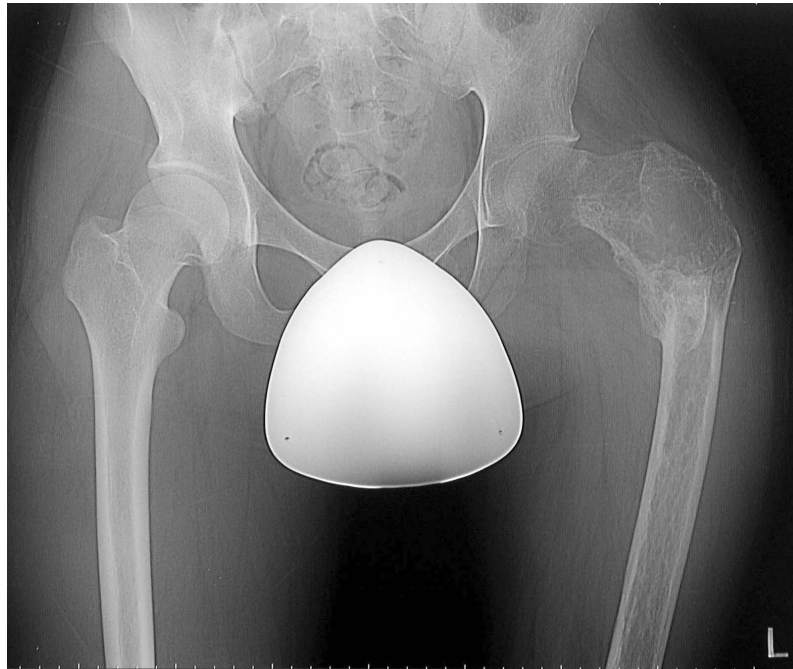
Plain radiography showing a 5cm x 5.5cm sized radiolucent lesion with ground glass appearance and marginal sclerosis in the left femoral trochanteric region.
